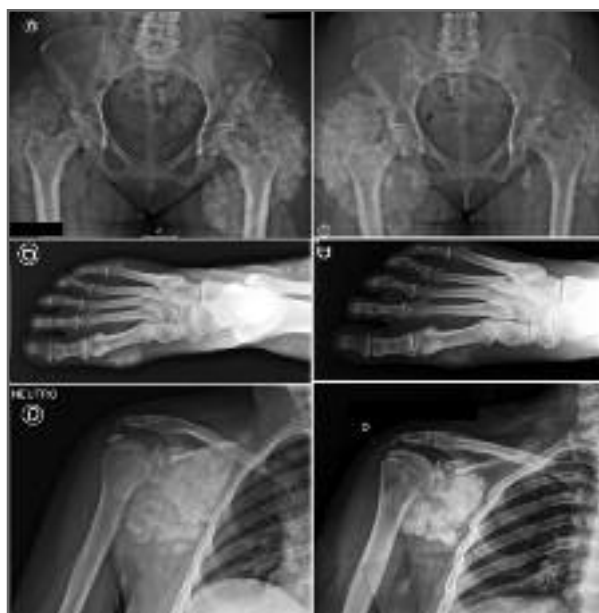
Radiographic images of pelvis, right shoulder and right foot before (left) and 6 months after treatment (right)
